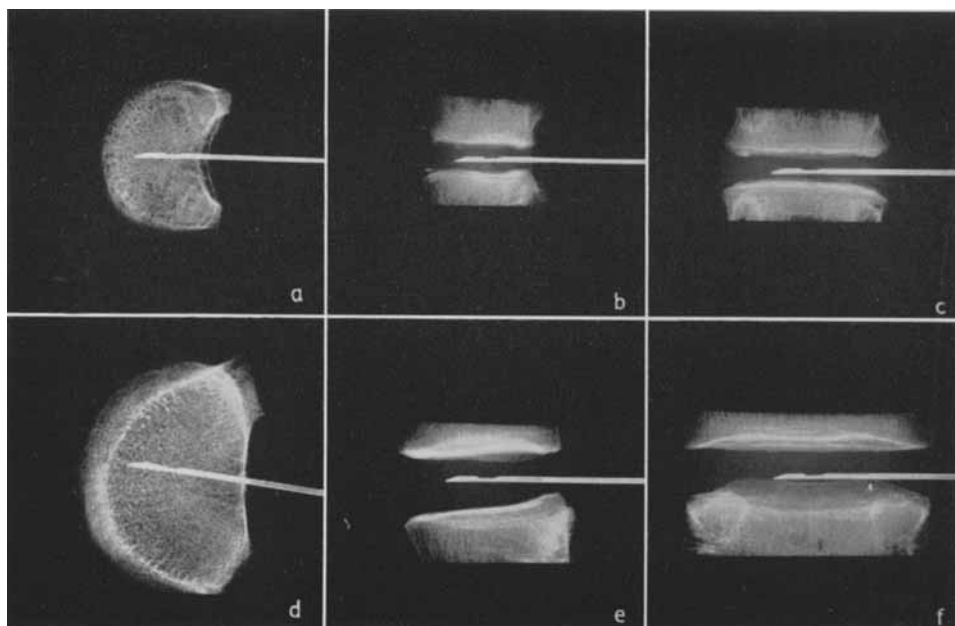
Roentgenographic appearance of the discs 267/59 - L 1 (a, b and c) and 604/58 - L 4, (d, e and f.) shown in fig. 13. As seen, the position of the needle inside the disc is checked by roentgenograms in two planes. The above roentgenograms have been classified as normal (0). Scale 1:2.
